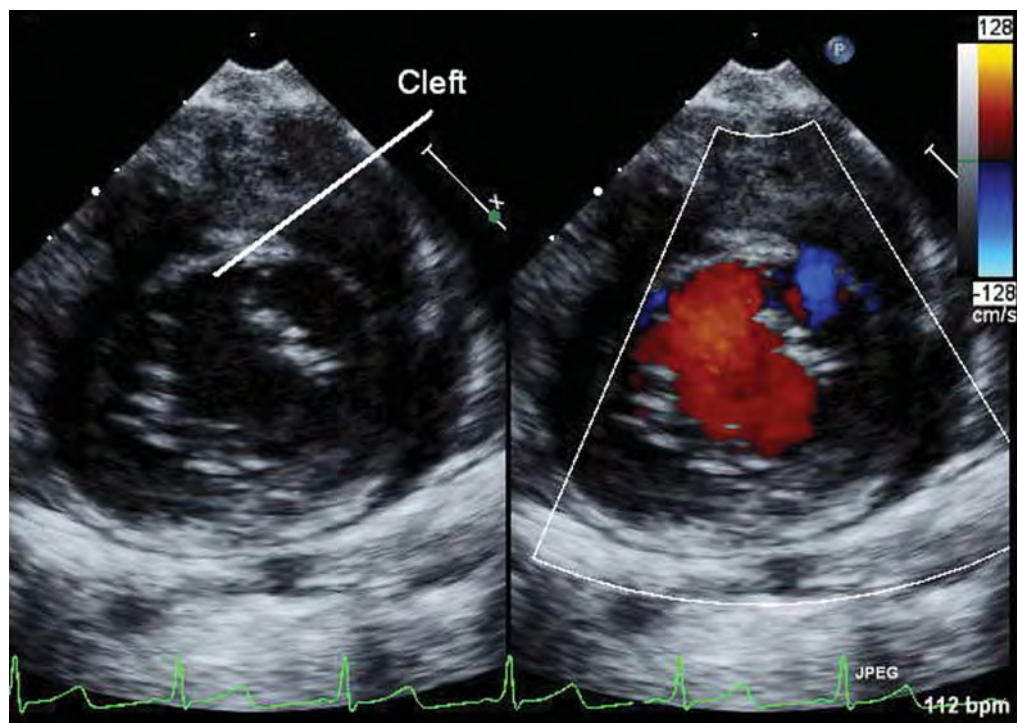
Parasternal short-axis view in color compare mode demonstrating the cleft in the left atrioventricular valve in a patient with incomplete common atrioventricular canal.
